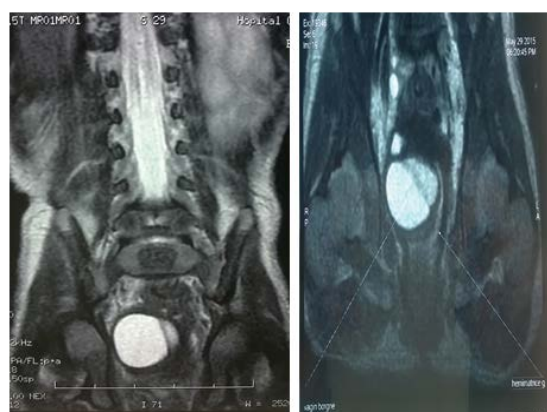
Magnetic resonance image showing hyperintense fluid collection in the right uterine cavity.
